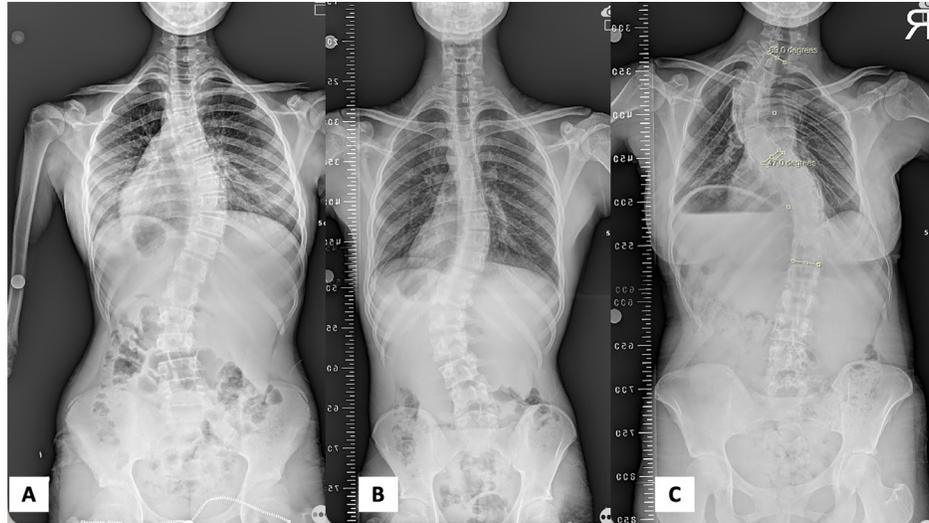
Representative radiographic patterns of scoliosis according to curve localization. (A) Main thoracic curve, (B) thoracolumbar curve, and (C) double thoracic curve
